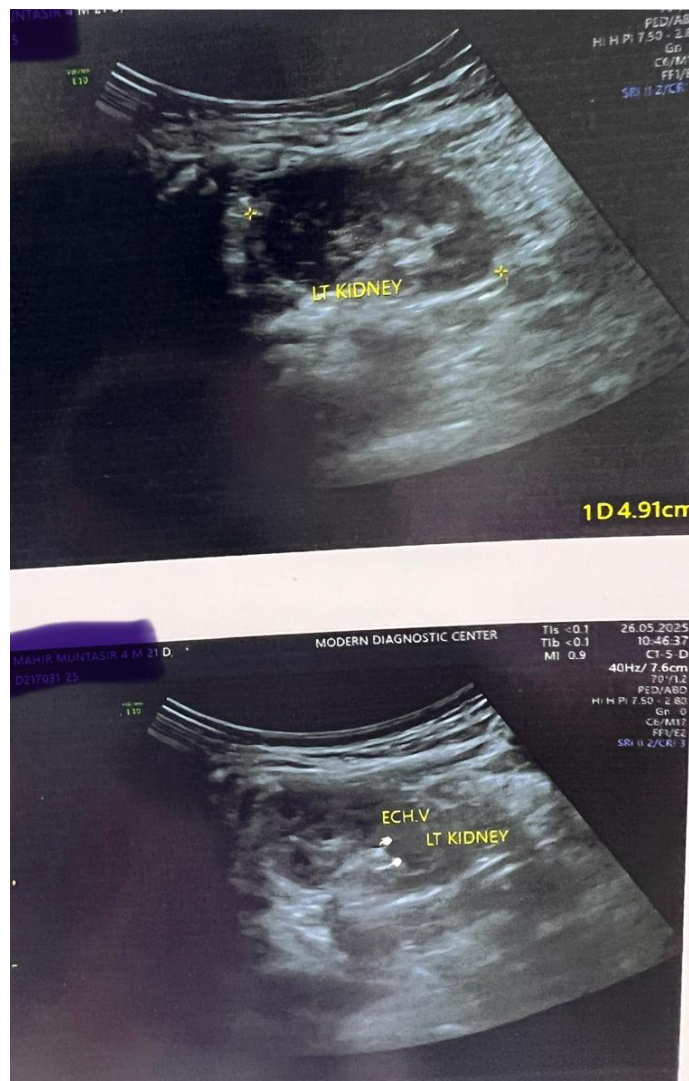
Ultrasound images of the kidneys
